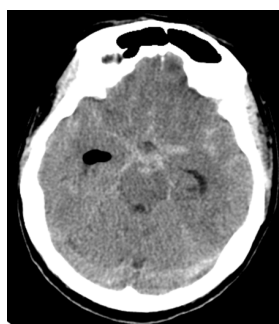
Admission Brain CT of admission, with SAH classified as a modified Fisher Scale 3.
